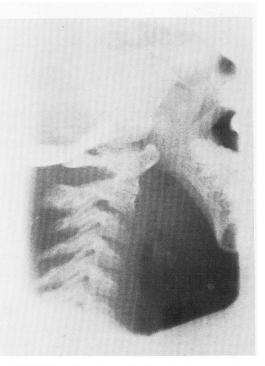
Sleeping supine lateral radiograph of the neck (taken from the cineradiographs) shows airway occlusion prior to surgery.
